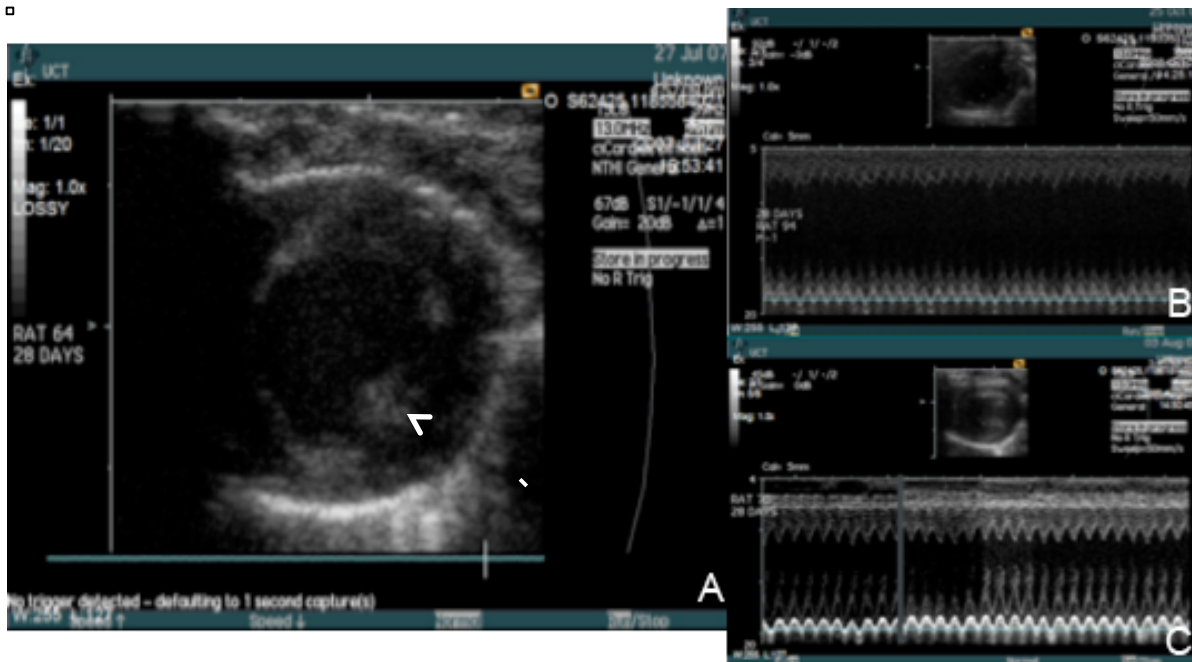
Representative echocardiographic images obtained on day 28 post surgery for analysis of cardiac function and ventricular remodelling. A 2D image (Fig.31A), and M-mode images of a large (Fig.31.B) and small infarct (Fig.31.C) taken on the level of the papillary muscle (white arrow in Fig.31.A) are shown.
